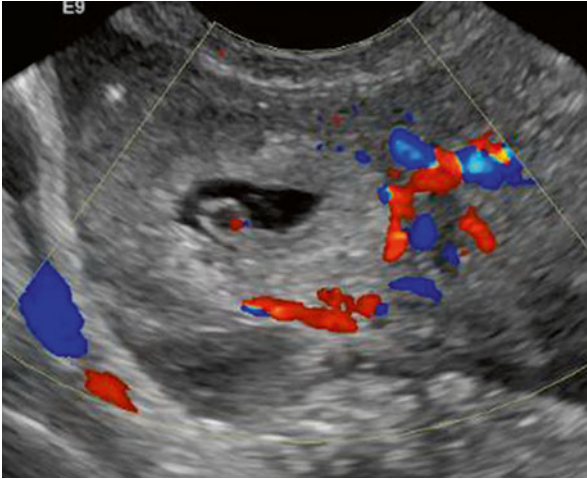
Tubal ectopic pregnancy by transvaginal ultrasound. Transvaginal ultrasound shows a hyperechoic ring containing a gestational sac in the right adnexa, with circumferential Doppler flow
